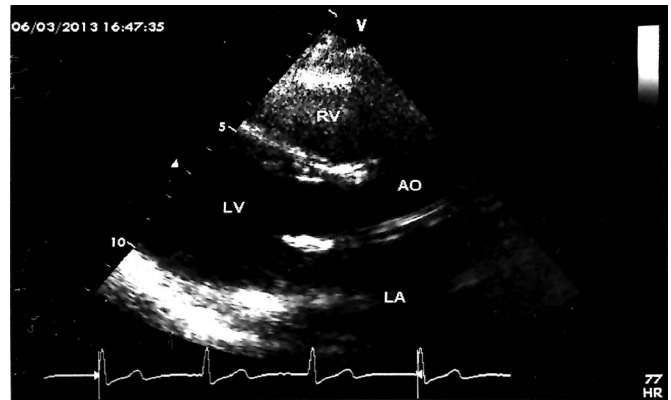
Parasternal long axis control echocardiogram 11 years and 2 months after operation of a female patient (FÖ), aged 17 at the time of operation, showing enduring enlargement of the aortic valve with no restriction or anomaly related to the aortic root. No aortic or mitral regurgitation was present. The patient had undergone Manouguian type aortic enlargement, aortic valve replacement, mitral valve replacement, and De Vega tricuspid valve plasty. LV indicates left ventricle; RV, right ventricle; LA, left atrium; Ao, ascending aorta.
